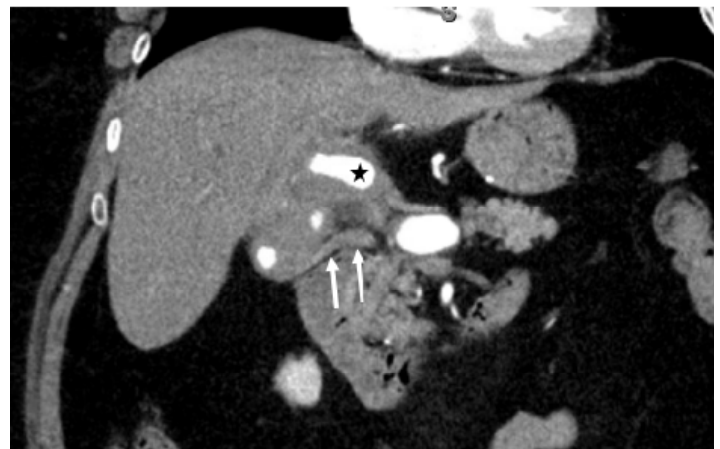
Coronal image of abdominal computed tomography with angiography showing a hepatic artery aneurysm (star) with an associated high-density common bile duct (arrows), indicating thrombosis in the biliary system.
